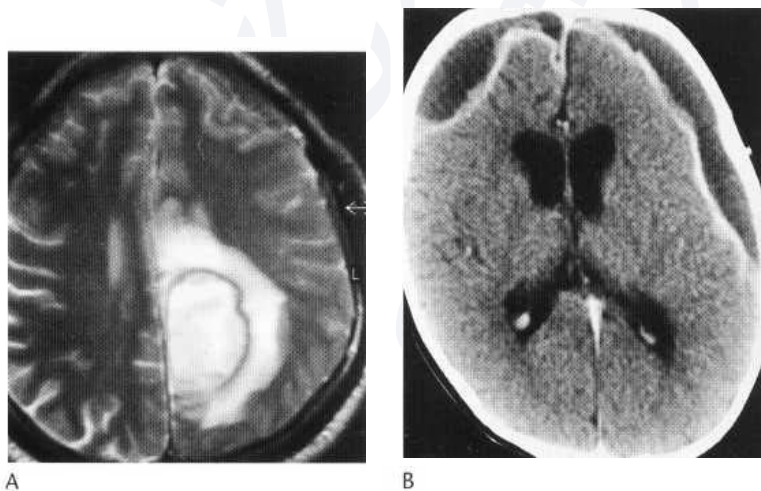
(A) Axial T₂-weighted image of a left parietal abscess and associated vasogenic oedema. The central contents are hyperintense but the low-signal rim is thought to be secondary to the paramagnetic effects of the free radicals present. (B) Axial post-contrast CT in a child demonstrating bilateral low-density subdural empyemas with enhancement of the inner membranes.
